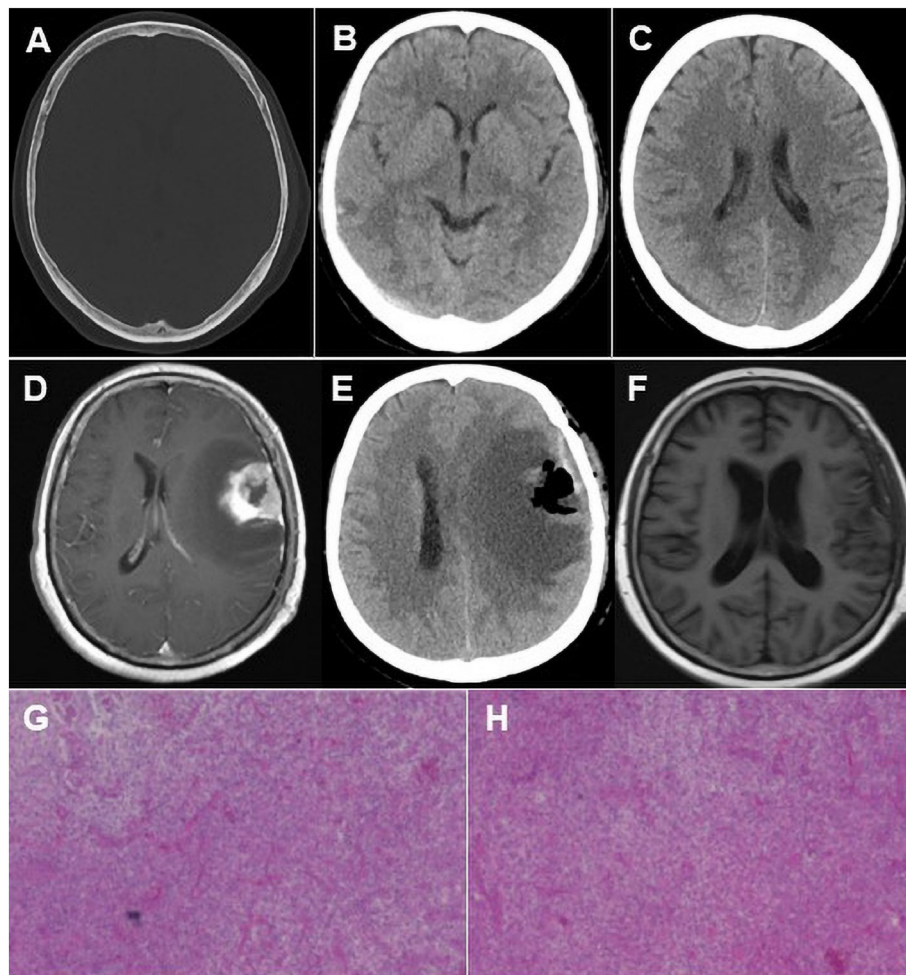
(A,B) CT image showed left temporal bone fracture; left temporal lobe subcutaneous hematoma with sphenoid sinus accumulation of blood; (C) 7.20 trauma discharge review CT: no abnormality was seen; (D) 11.02 after enhanced scanning: left frontotemporal lobe occupying foci, considering the possibility of high-grade glioma; (E) 6 h after the operation, CT showed no hemorrhage; (F) 7 months after the operation, MRI review: Left frontal, temporal, and parietal lobe edema with no signs of tumor recurrence; (G,H) Pathological findings showed a high-grade glioma, which was considered a glioblastoma (CNS WHO grade 4).
